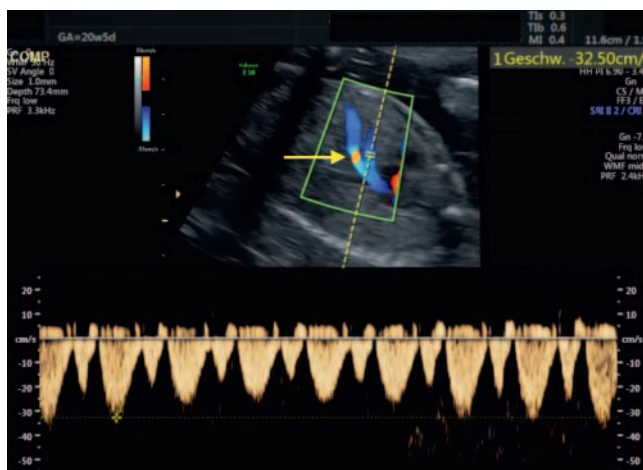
Images of every Doppler sonographic examination should be documented to show the envelope and its measurement.
